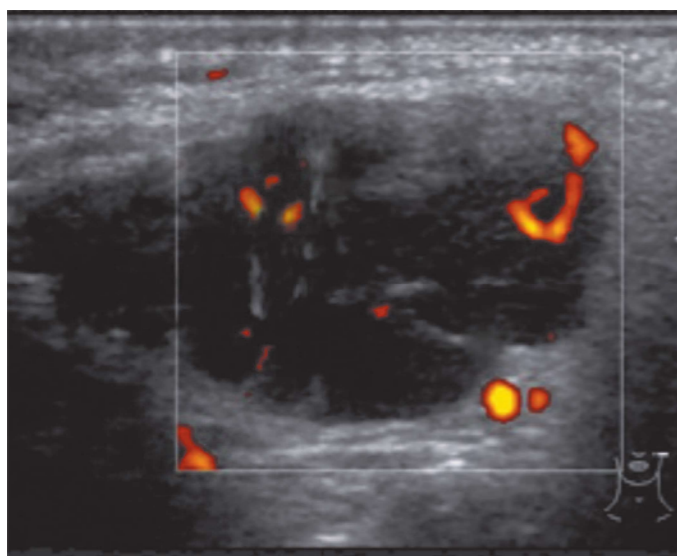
Adenolymphoma of the parotid gland. Moderate vascularization of the tumor – up to five vascular signals are visible with power Doppler ultrasound.*
